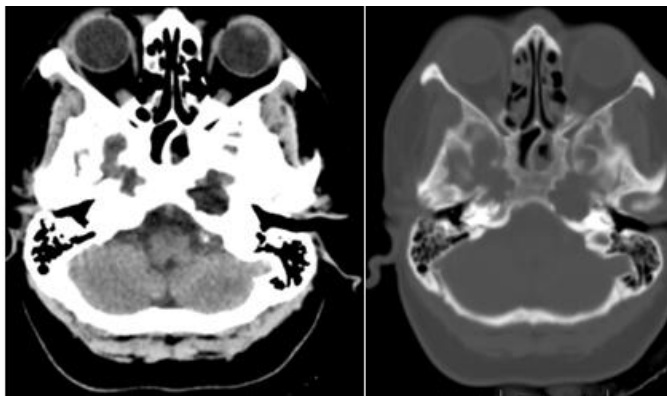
CT (Axial soft tissue, Fig 3B (Axial Bone window). HRCT scan of temporal bone was performed which revealed sharply demarcated lesion with a thin cortical bone outline at the left petrous apex
